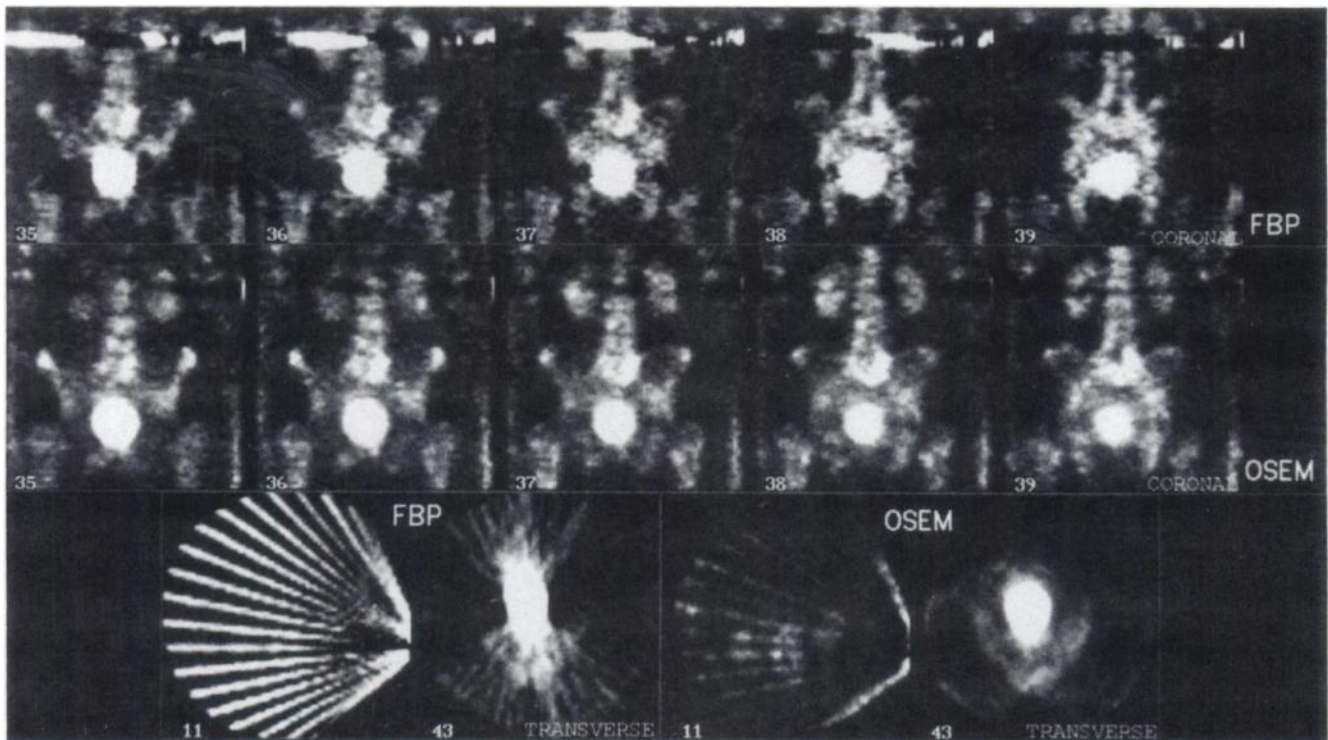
Important artifacts were generated by filtered backprojection (FBP) after reconstruction of pelvic and lumbar SPECT images in patient with paravenous injection in left arm, which entailed low statistics counting. Patient was not able to raise the arms and presented with important bladder residual activity. Ordered-subset expectation maximum (OSEM) helped with both artifacts, erasing L1 (paravenous injection, transverse slice 11) and erasing both hips (bladder activity, transverse slice 43). Images remained unsatisfactory, but general outlook improved with OSEM.
